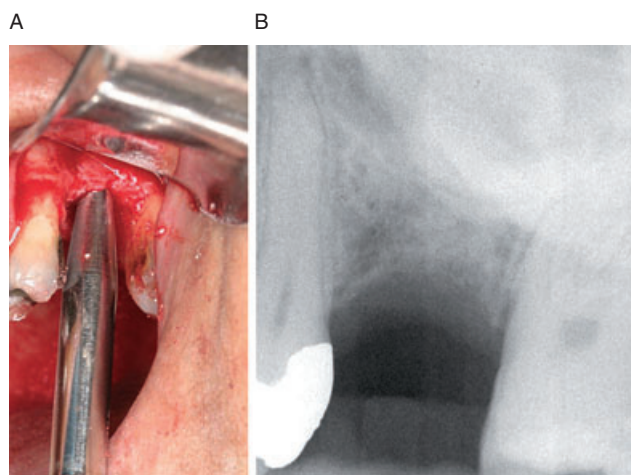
Bone graft injector in osteotomy (A). Periapical radiograph after bone graft injection (B).
